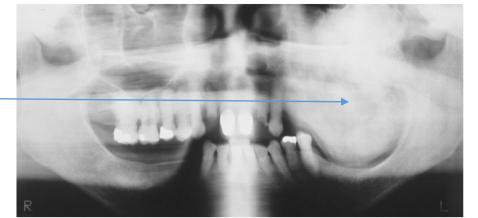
Priores Dysplasia. Panoramic radiograph of the patient shown in Fig. 14-31. A diffuse "ground-glass" radiopacity is evident. (Courtesy of Dr. Richard Brock.)
